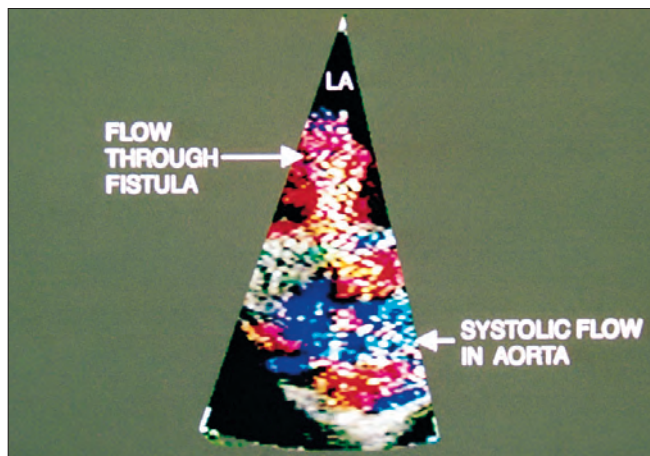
Colour Doppler ultrasonography showing the fistula.
